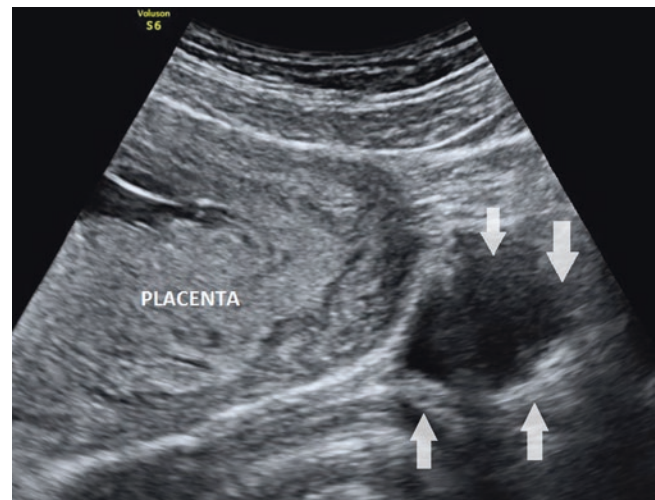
Transabdominal sonogram of subchorionic hematoma (white arrows)
